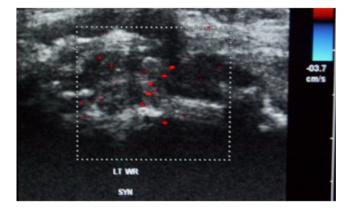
Colour Doppler ultrasound of the left wrist showing synovial thickness equal to 5.6 mm with active pannus and five hot spots synovial Doppler score equal to 2.
